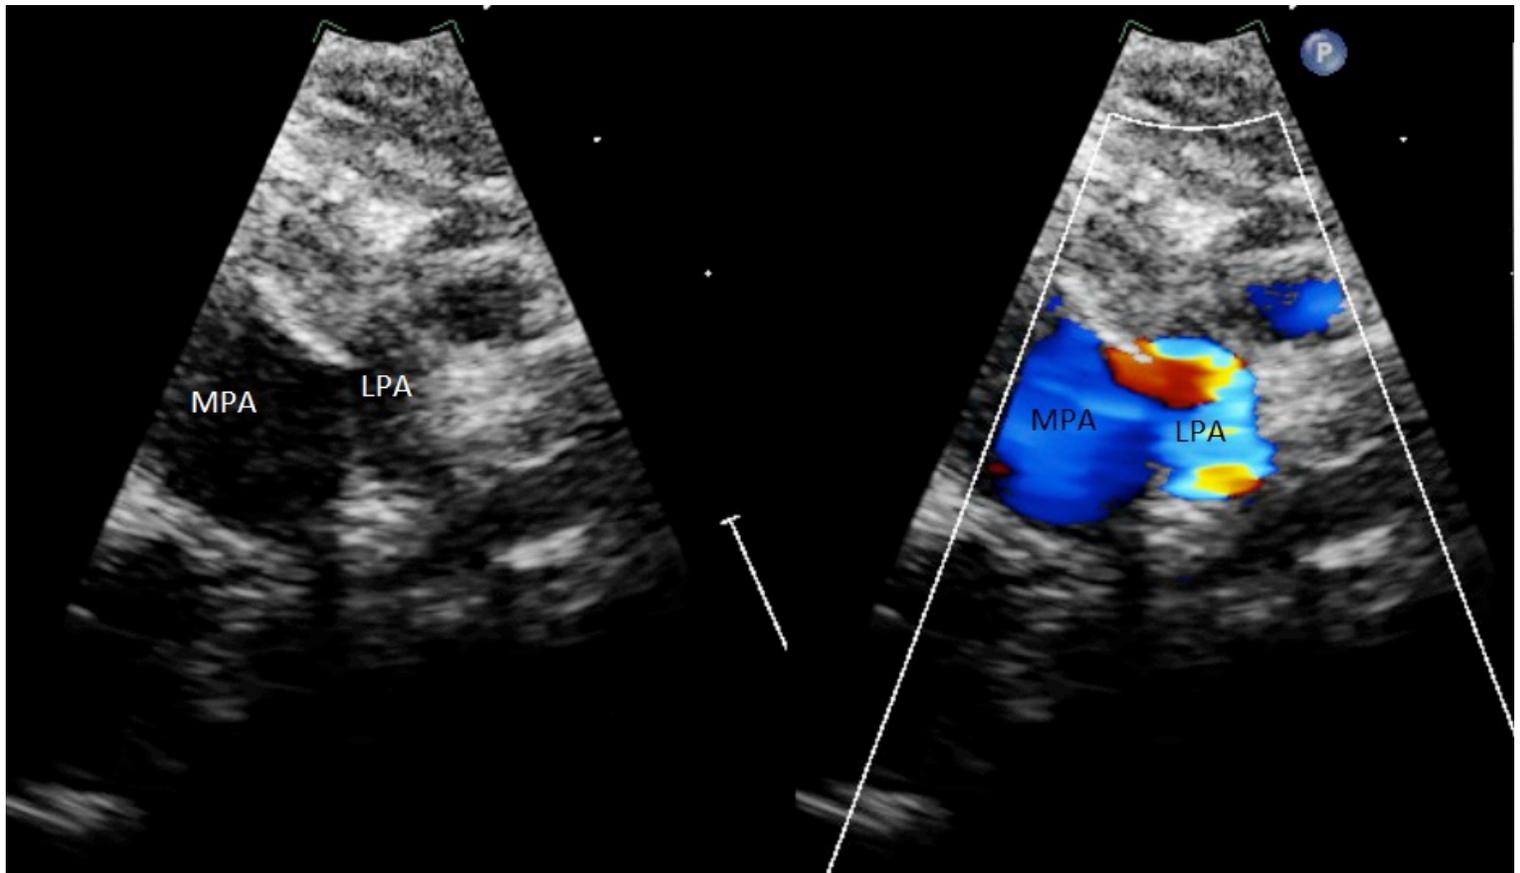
Post-surgical echocardiogram: parasternal short axis with color flow showing reimplantation of the left pulmonary artery to the main pulmonary artery.
